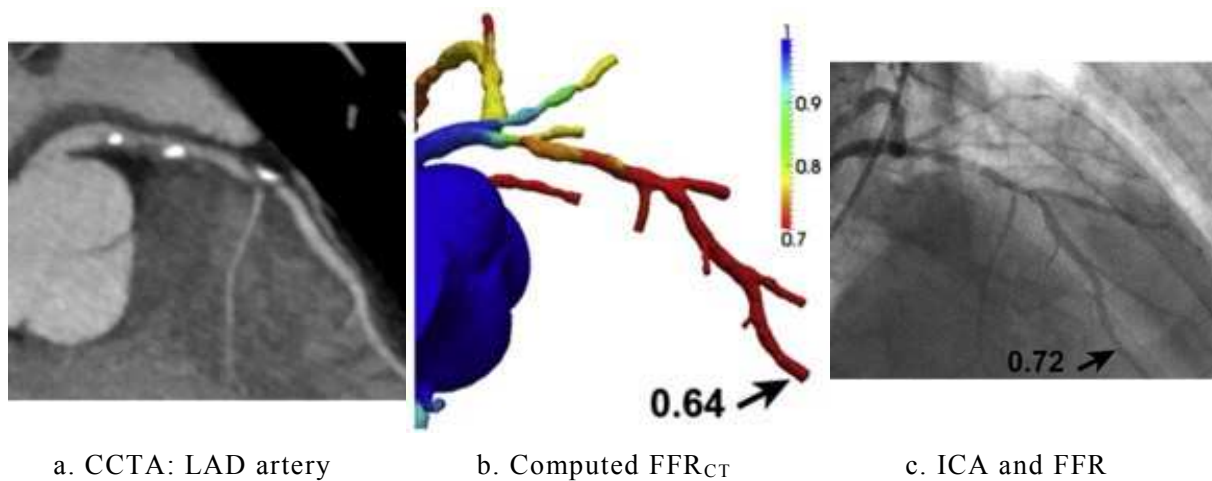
HeartFlow® FFR_{CT} results for a multivessel CAD case [45]
